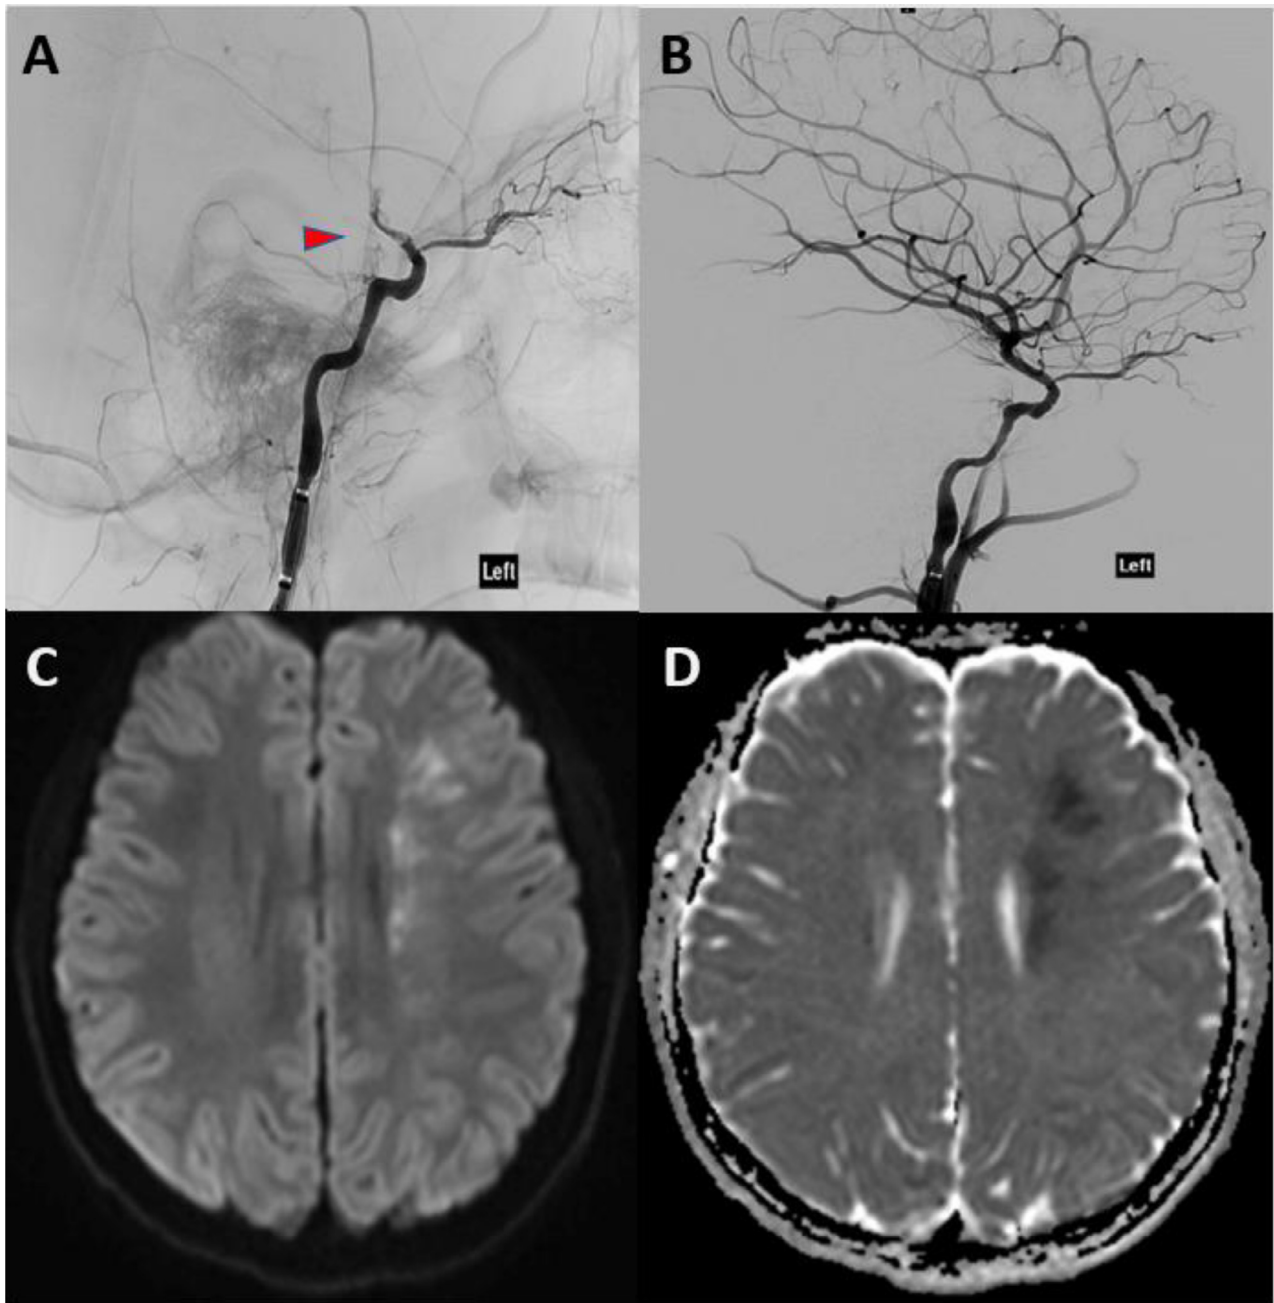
A: Lateral angiography showing a left internal carotid artery occlusion in the supra-clinoid segment. B: Lateral angiography showing complete reperfusion of the internal carotid artery post-endovascular procedure. C: MRI brain – Diffusion-weighted sequence showing restricted diffusion correlating with a small acute border-zone infarction in the left middle cerebral artery territory. D: MRI brain – Apparent diffusion coefficient sequence showing a hypointense area correlating with a small acute border-zone infarction in the left middle cerebral artery territory.
